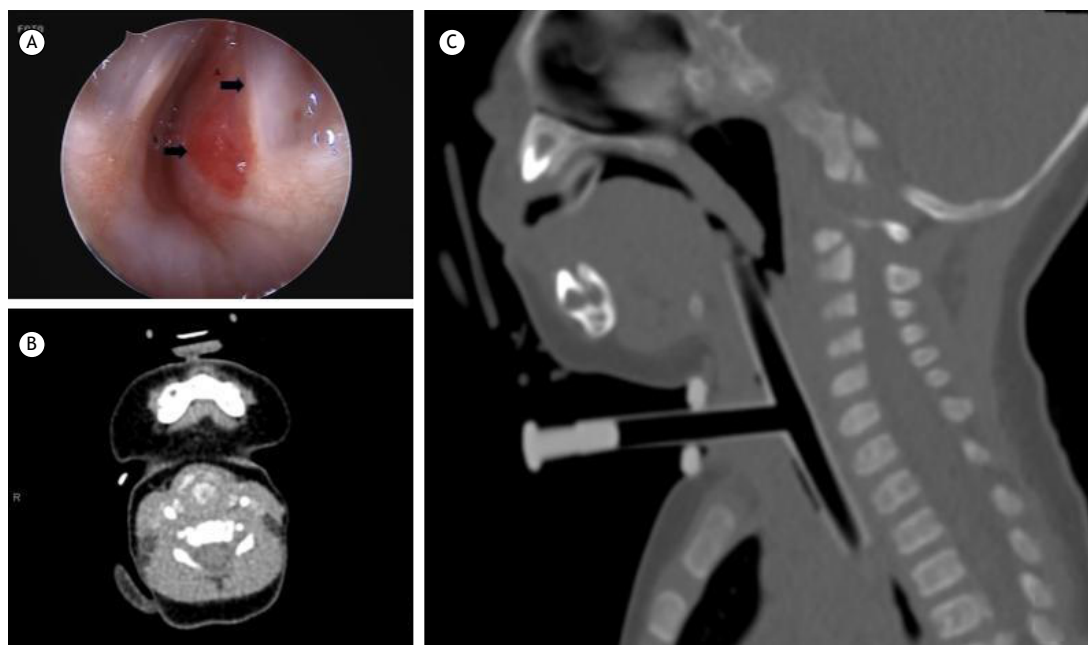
A. Laryngoscopic image showing right subglottic hemangioma (arrows), with airway obstruction. A (arrow): Right vocal cord; B (arrow): Subglottic hemangioma obstructing the upper airway. B. Contrast-enhanced axial CT scan showing obstructive subglottic hemangioma with characteristic intense immediate enhancement after IV contrast injection. C. Sagittal CT scan showing silicone T-tube placement, with the upper end sitting above the vocal folds.
